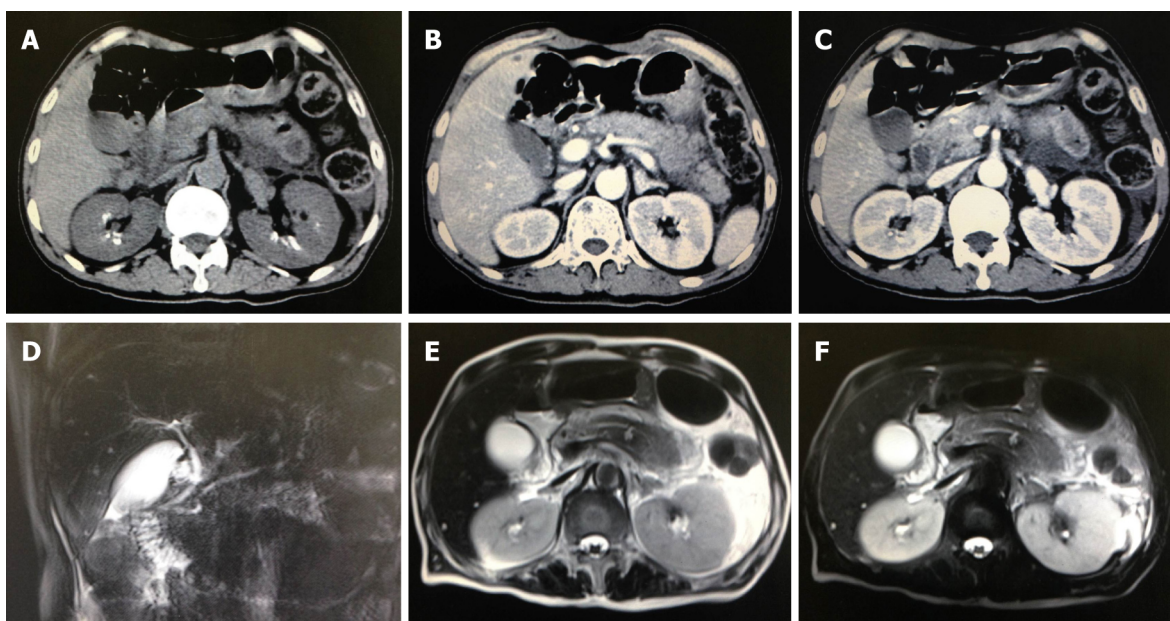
Abdomen computed tomography scan and magnetic resonance imaging. A-C: Abdomen computed tomography demonstrated double kidney stones and a swelling pancreas. The exudation is focused on the surrounding of pancreas body and tail; D-F: Abdomen magnetic resonance imaging similarly revealed pancreatic tail contusion and exudative changes around the pancreas. There were no obvious changes in the biliary system.
